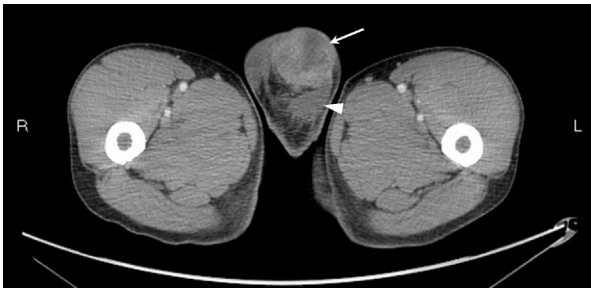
Pelvic CT scan showing heterogenous tumor in left scrotum (arrow) and left testis (arrowhead).
